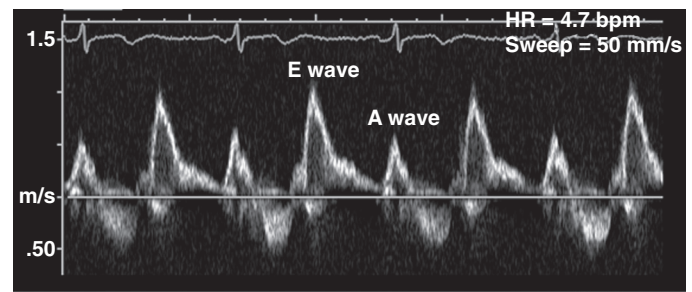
■ Normal mitral inflow profile as measured by transthoracic pulsed wave Doppler at the tips of the mitral leaflets. It is characterized by an early filling phase (E wave) followed by atrial systole (A wave), which results in additional filling. These filling parameters are related to intrinsic diastolic myocardial properties and can be influenced by many different factors (see text).
